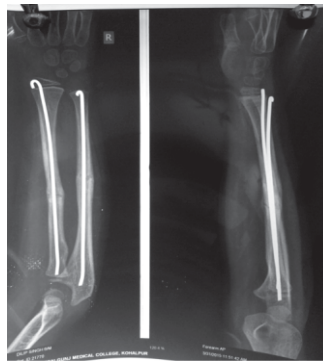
Follow up X-ray at 8 weeks
